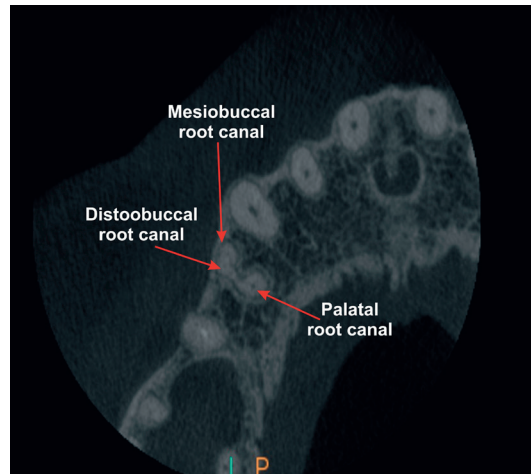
Cone beam computed tomography scanning in the horizontal plane of the apical third of the root-tooth 14
